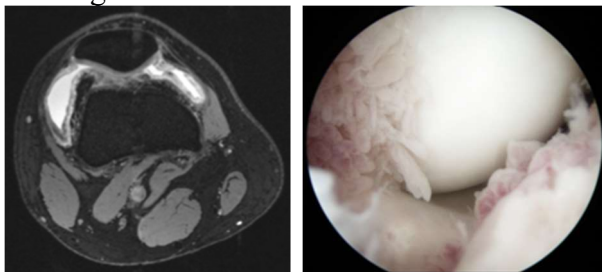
MRI image of the knee showing areas of synovial hypertrophy and arthroscopic images of villi like synovial proliferation.
